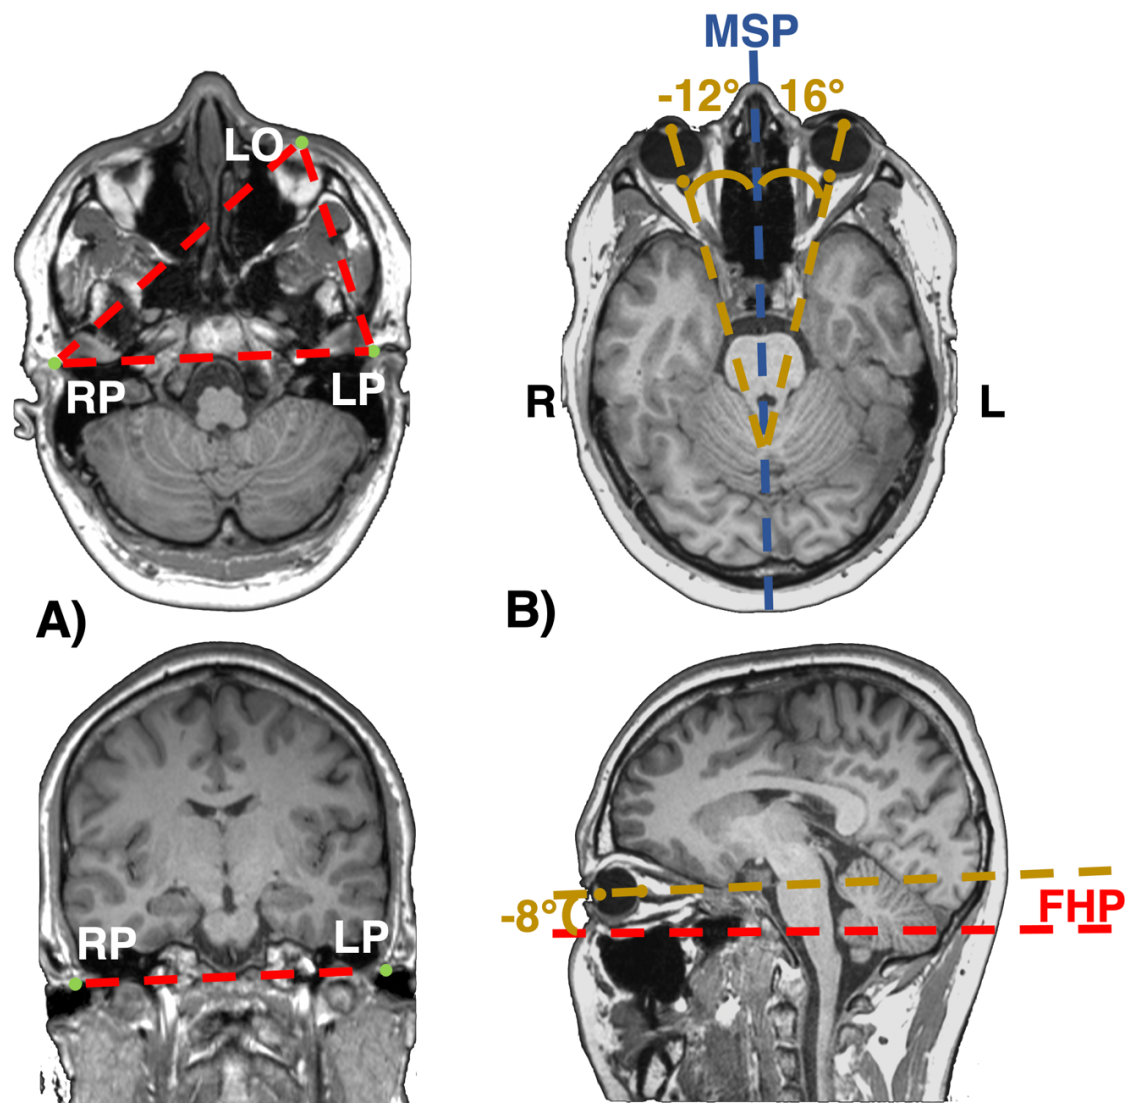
Lateral and vertical gaze angles were measured with respect to Frankfort horizontal plane of the skull. A) High resolution T1-weighted sagittal scan oriented to horizontal and coronal planes to show left and right porion and left orbitale point selections and the resulting Frankfort horizontal plane (FHP) in red. B) Lateral and vertical gaze vectors measured against the FHP and midsagittal planes (MP).
